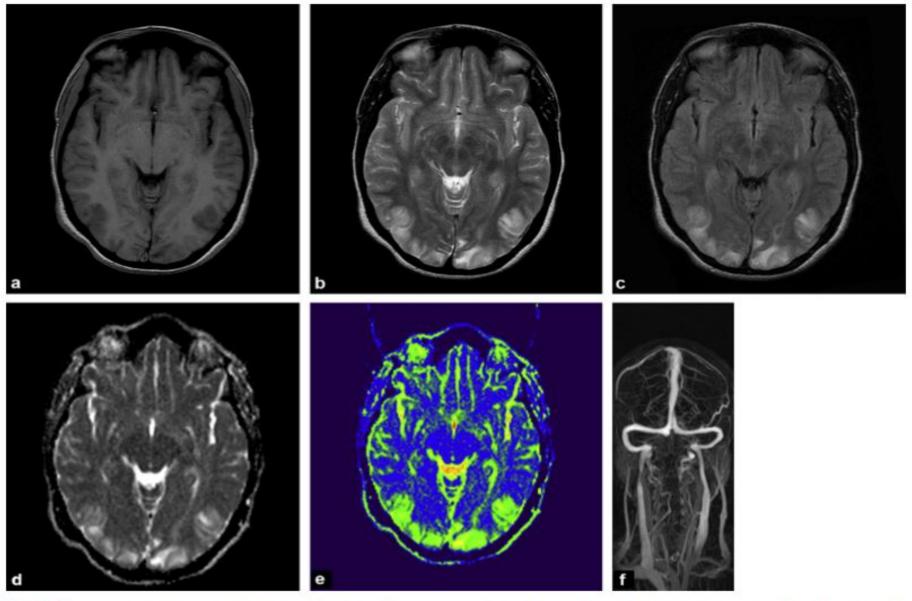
Female aged 31, on dialysis, who had presented with her first partial epileptic seizure against a background of hypertension (systolic blood pressure of 230 mmHg). The MRI showed characteristic diffuse, bilateral, posterior lesions. The neurological signs quickly disappeared after anti-hypertensive treatment: a: T1-weighted axial view: low signal intensity occipital lesions; b: T2-weighted axial view: high signal intensity occipital lesions; c: axial view on FLAIR sequence: high signal intensity occipital lesions; d and e: axial views – diffusion-weighted sequence: the apparent diffusion coefficient mapping in grey and in colour shows high signal intensity from the lesions pointing to a raised diffusion coefficient; f: 3D MR angiography: eliminates the differential diagnosis of cerebral thrombophlebitis by demonstrating that the venous sinuses are patent.
